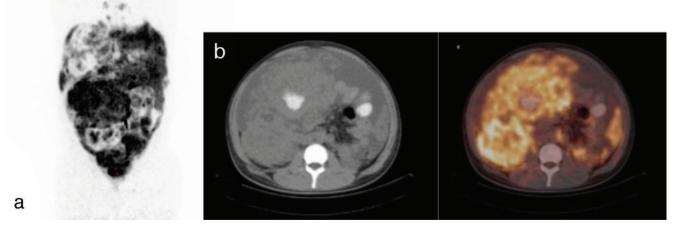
MIP (a), transaxial CT (b), and fusion <sup>18</sup>F-FDG PET/CT images of a 15-year-old male patient. Abdominal lymph node biopsy revealed a highgrade malign B-cell lymphoma (Burkitt's lymphoma). Multiple hypermetabolic mediastinal, abdominal, pelvic lymph nodes, massive abdominal fluid, and bone marrow involvement were seen on <sup>18</sup>F-FDG PET/CT imaging
